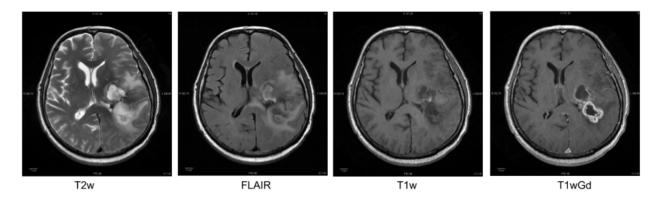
This figure shows some of the basic MRI modalities used for extracting important clinical inforamtion about brain tumors like glioblastomas.
